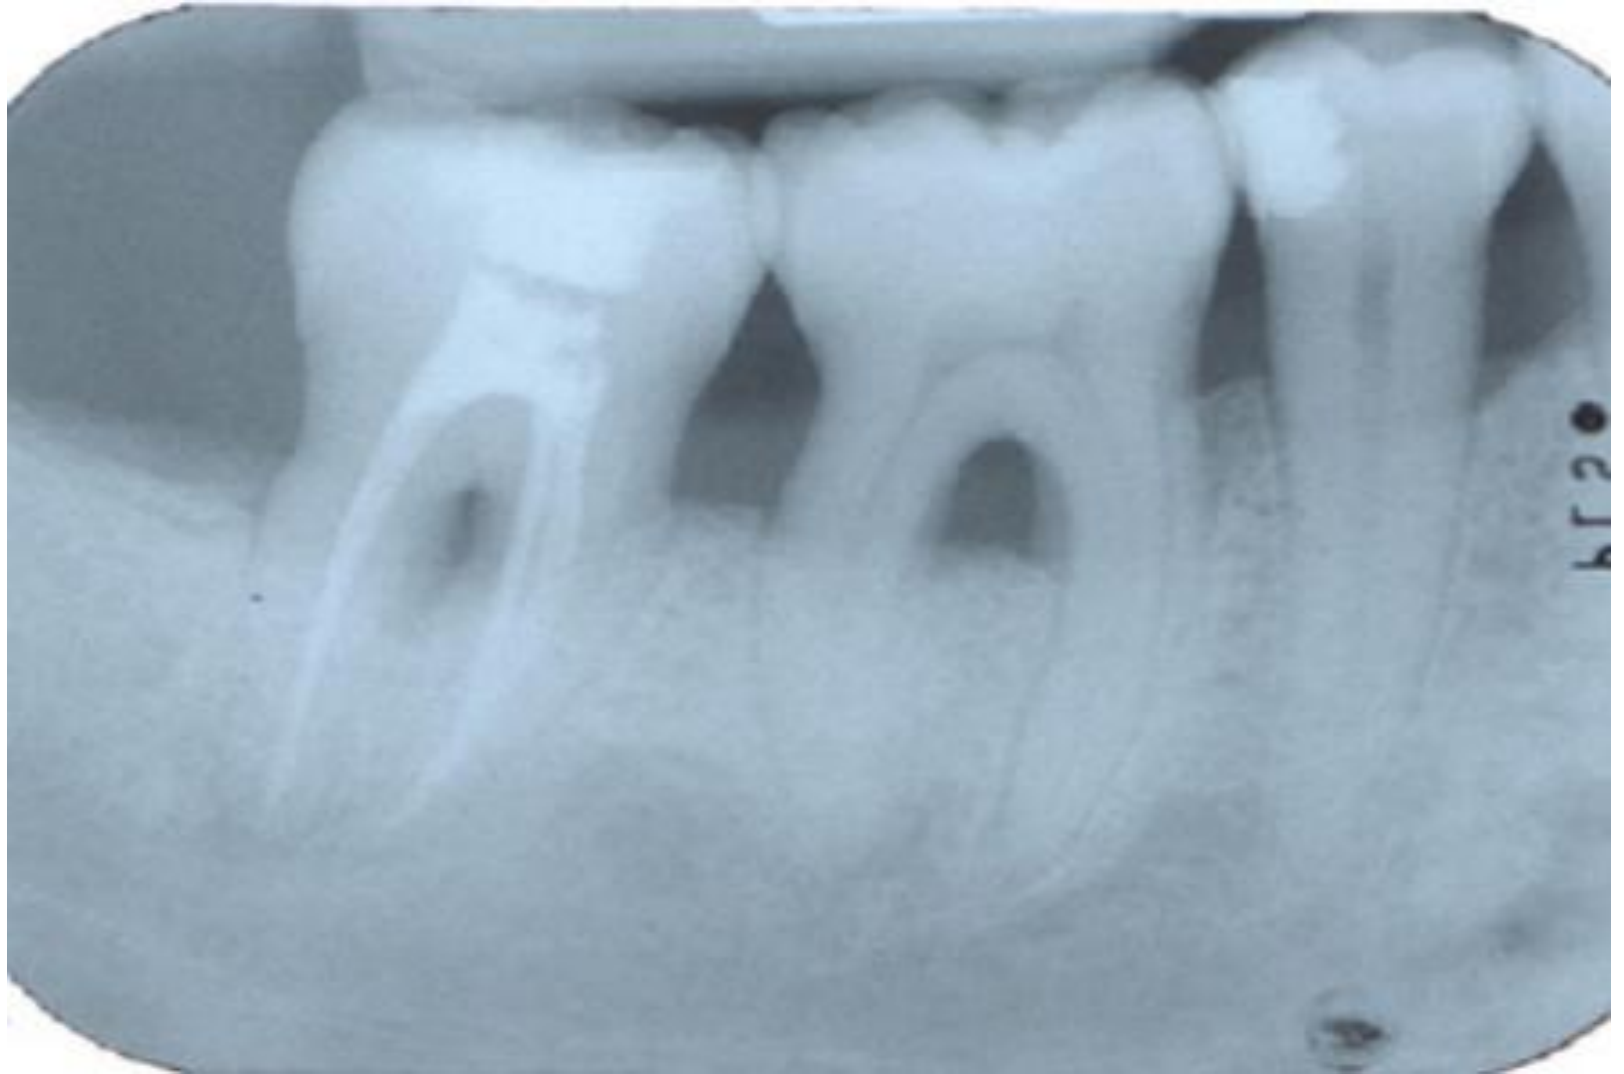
Tunnel preparation of a degree III-involved mandibular molar. Radiograph (a) and photograph (b) showing a wide inter-radicular space where self-performed plaque control can be obtained by the use of an interproximal brush.
